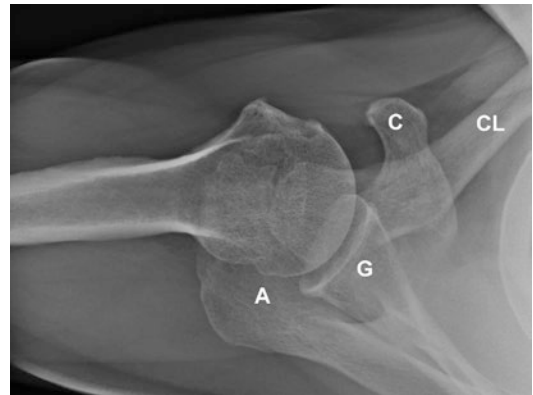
Axillary view radiograph of a normal shoulder. The humeral head is centered on the glenoid (G). The coracoid (C) is anterior. The acromioclavicular joint projects over the humeral head (A acromion, CL clavicle)
